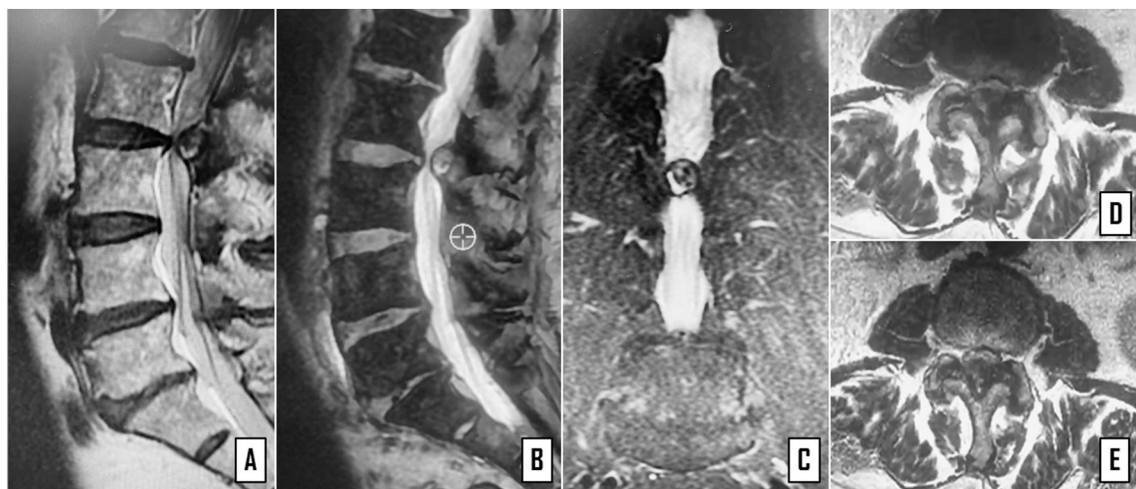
Magnetic resonance imaging (MRI) showed a heterogeneous intraspinal and extradural mass adjacent to the inter-apophyseal joint in sagittal view (A, B) and in axial view (C) with radicular and dural compression (D, E) at L2-L3 of the lumbar spine.
